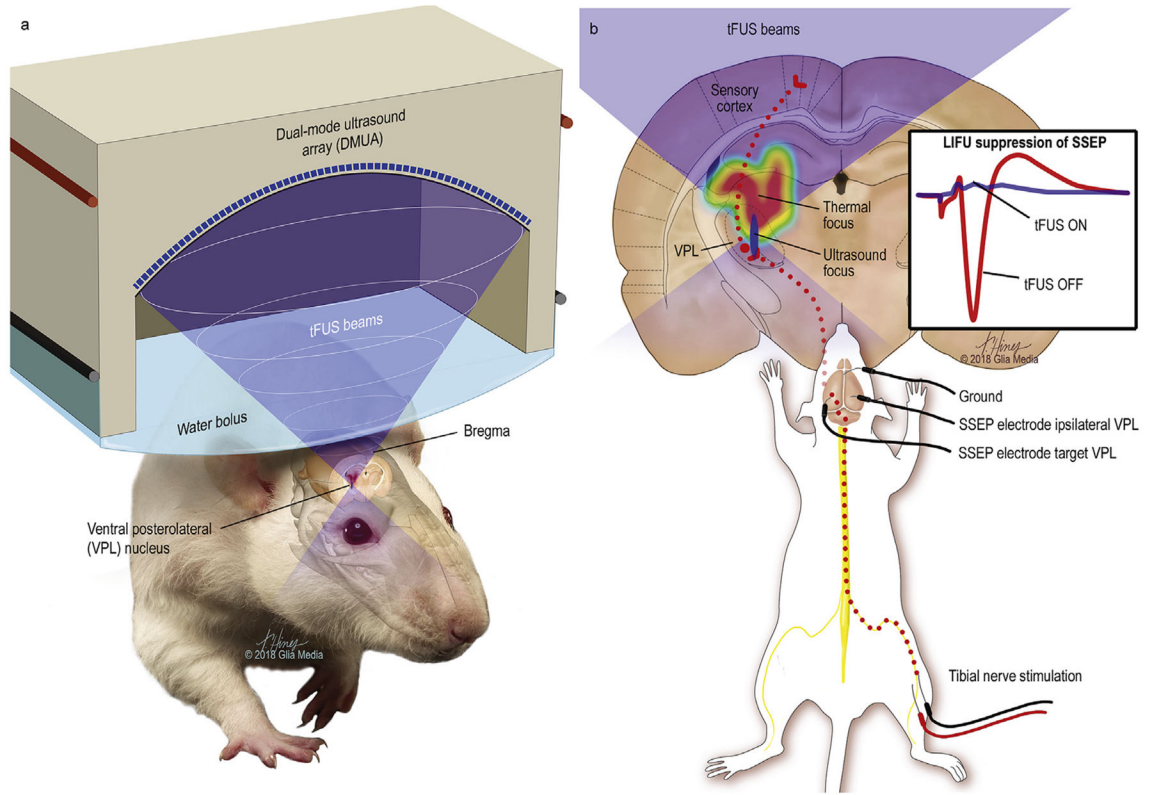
Transcranial-focused low-intensity ultrasound neuromodulation.
